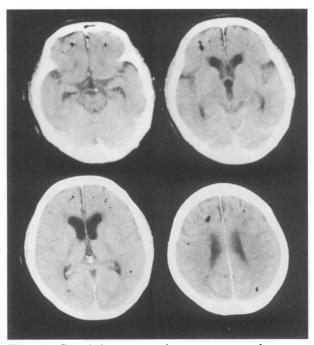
Cranial computed tomograms of a cerebral arterial air embolism. Many circular-shaped low-density areas can be seen in the parenchyma of the cerebrum.
